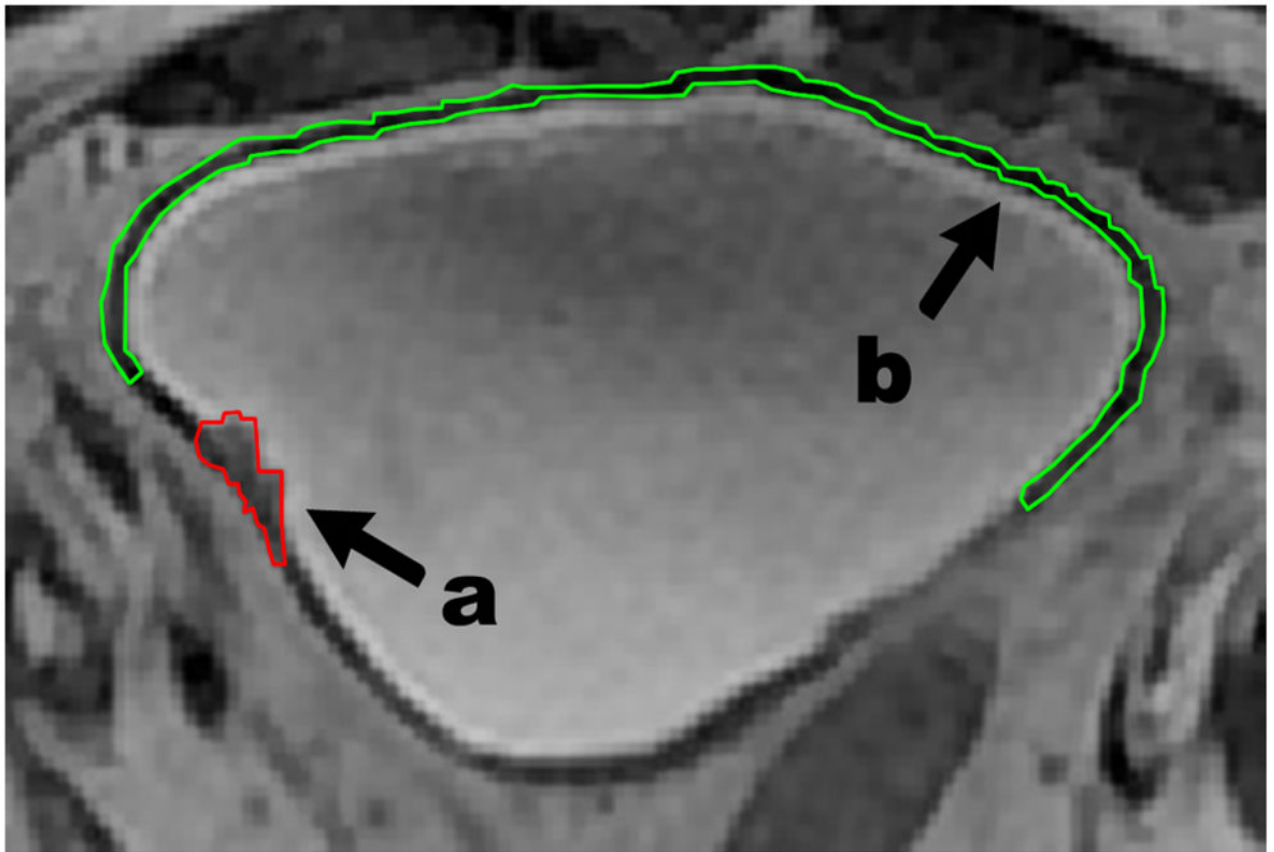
Patient's magnetic resonance image with outlined regions of interest (ROIs). (a) ROI for carcinoma neoplasm; (b) ROI for bladder wall tissue.
